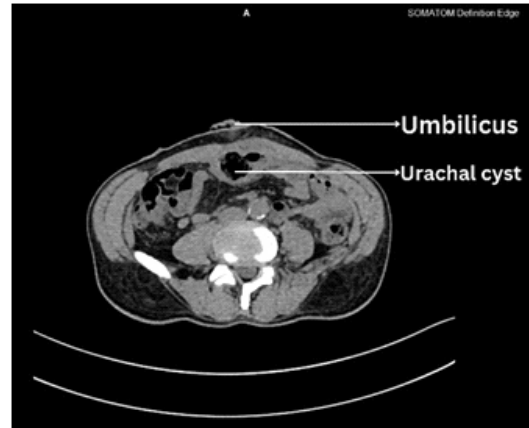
A Computed tomography (CT) image showing the urachal cyst below the umbilicus confined to the pre-peritoneum.
